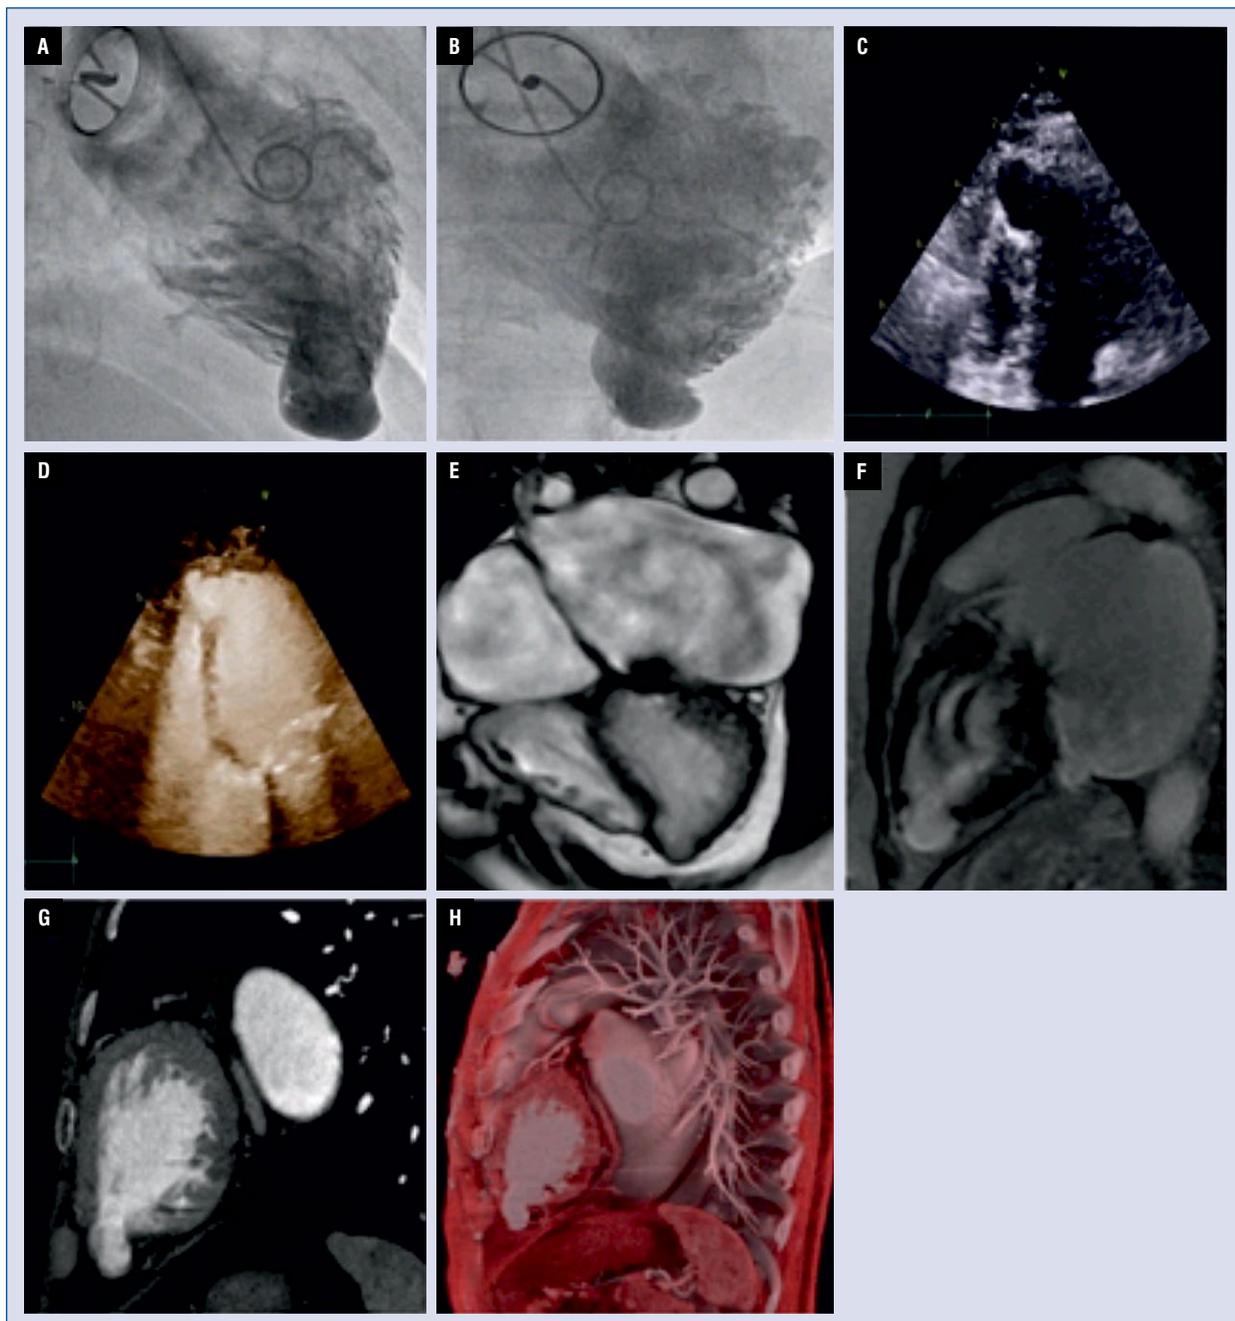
Multimodality cardiovascular imaging showing apical left ventricular pseudoaneurysm in the patient; A, B. Contrast invasive ventriculography: left (A) and right (B) anterior oblique views, revealing a small protrusion in the apical segment of myocardial wall. Mitral prosthetic valve was also noticed; C, D. Two-dimensional transthoracic echocardiogram without (C) and with contrast (D) showing the apical protrusion; E, F. Cardiac magnetic resonance: massive left atrial dilatation with a ventricular wall-defect at the apex of the left ventricle (E), and epicardial late gadolinium enhancement (F); G, H. Gated computed cardiac tomography in sagittal view (G) and after three-dimensional reconstruction (H) showing the same findings.
